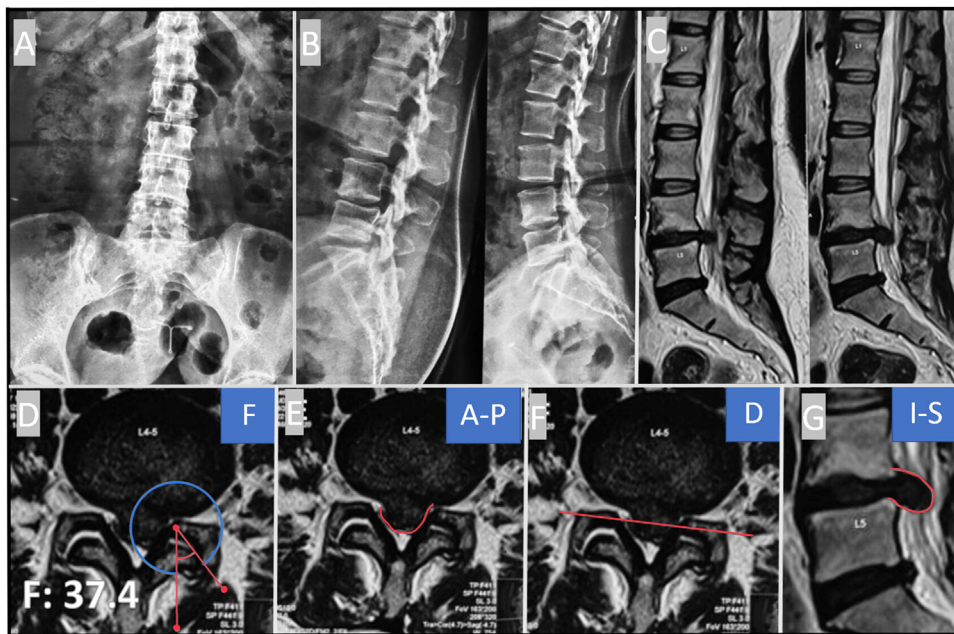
FAPDIS description of transforaminal approach – A and B (X-ray LS Spine AP and Lateral): showing stable spine. (C) Sagittal T2 MRI showing Dorsal and inferior disc extrusion at L4/L5 level. (D–F) (FAPDIS Calculation): (D) Facet angle 37.2 (F2). (F) Anterior disc pathology without any posterior offending pathology. (D) Dorsal far soft disc herniation. (F) Inferior near disc herniation (FAPDIS calculation F2A1A1PODfsInS0; Total score (TF:IL = 4.5: 4.5).
